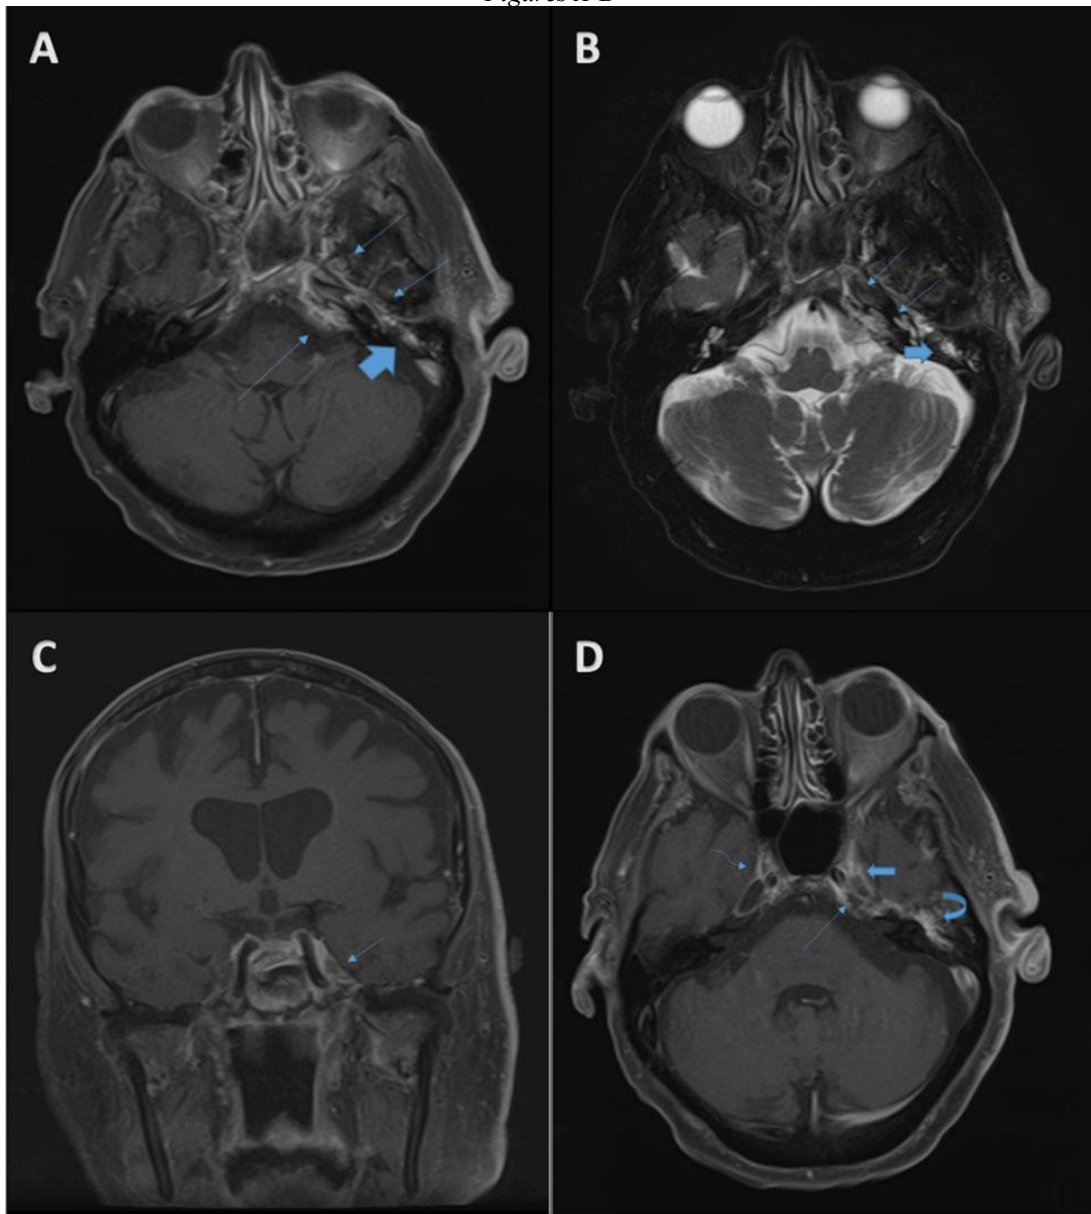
Axial T1 fat saturated MRI image through temporal bones after administration of IV gadolinium is showing abnormal heterogeneous enhancement of the left petrous apex with adjacent mild meningeal thickening and enhancement (thin arrows) consistent with apical petrositis (petrous apicitis). Partial enhancement of the left mastoid air cells are consistent with mastoiditis.
